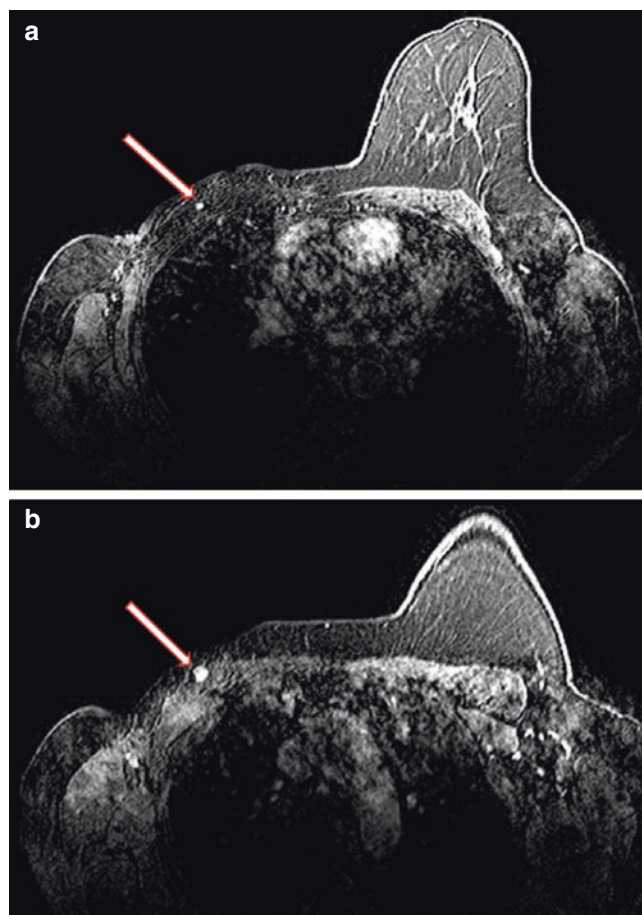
MRI images showing recurrences within the pectoralis major muscle in two different foci (a, b) of a 51-year-old postmenopausal patient who underwent MRM one year ago with a diagnosis of triple-negative, T4-invasive ductal carcinoma
